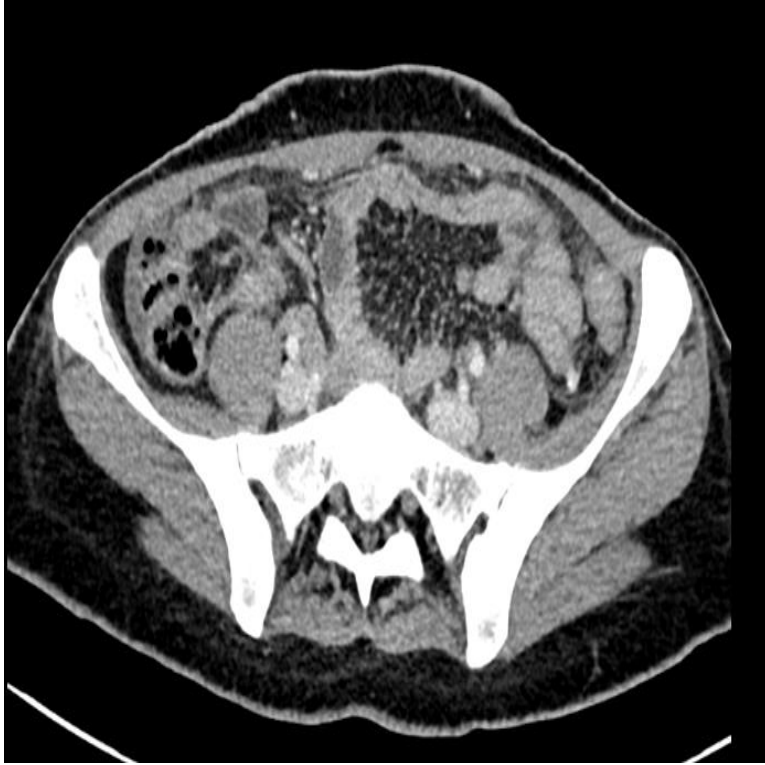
Axial view on CT scan showing collapsed bowel loops in the pelvis
